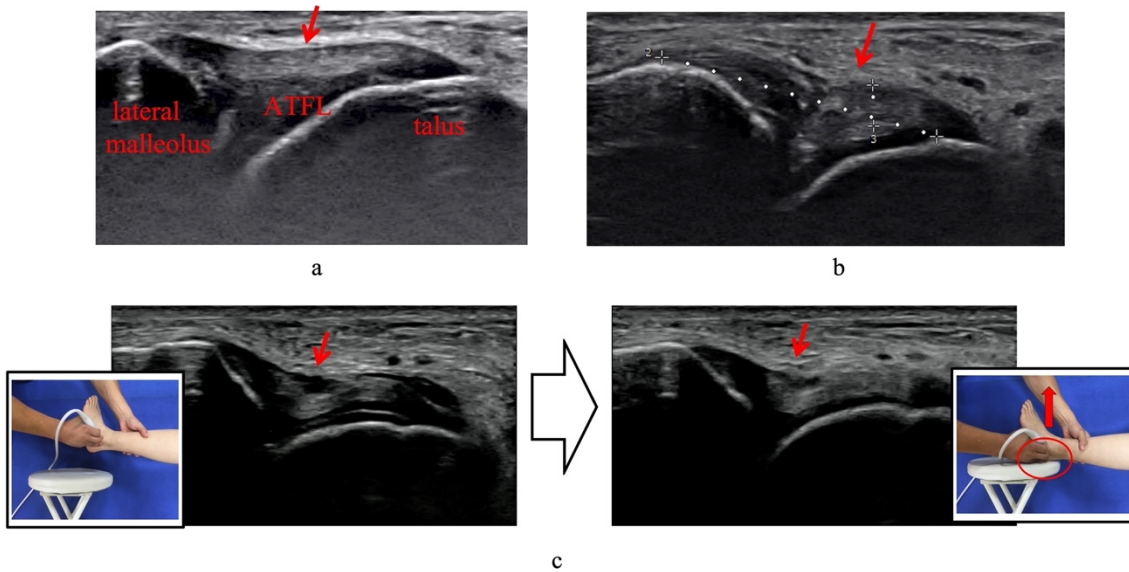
Ultrasonographic classification of ATFL injury
